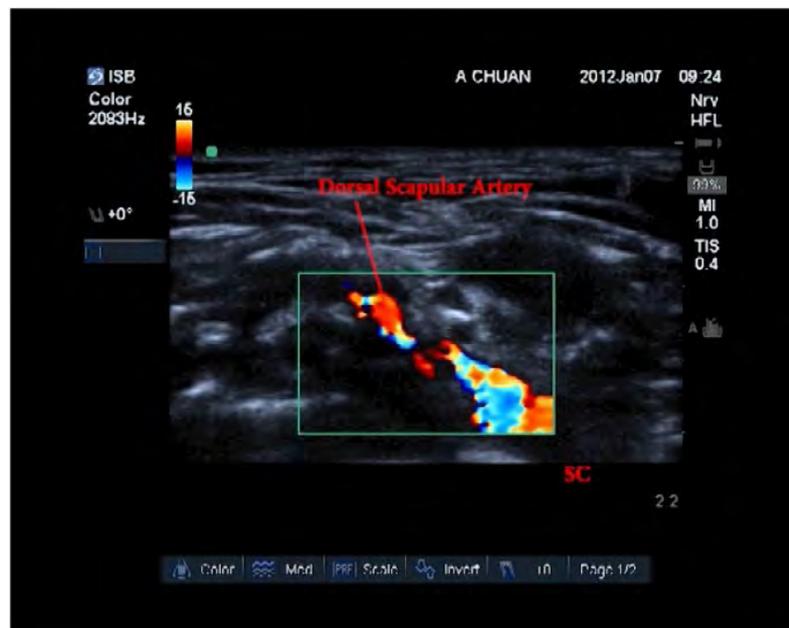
Same patient as above, with Colour Flow Doppler over the dorsal scapular artery.
